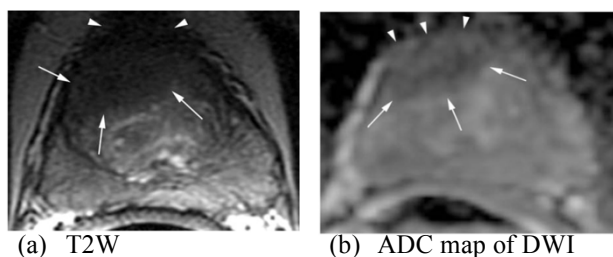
MRI of the prostate. (a) Axial T2-W FSE image of the mid-third of the prostate. Note the large hypointense area in the anterior portion of the gland (white arrows). (b) ADC map of DWI, Note the area with reduced ADC values suggesting tumor in the anterior gland (white arrows) with ECE (white arrow heads).
